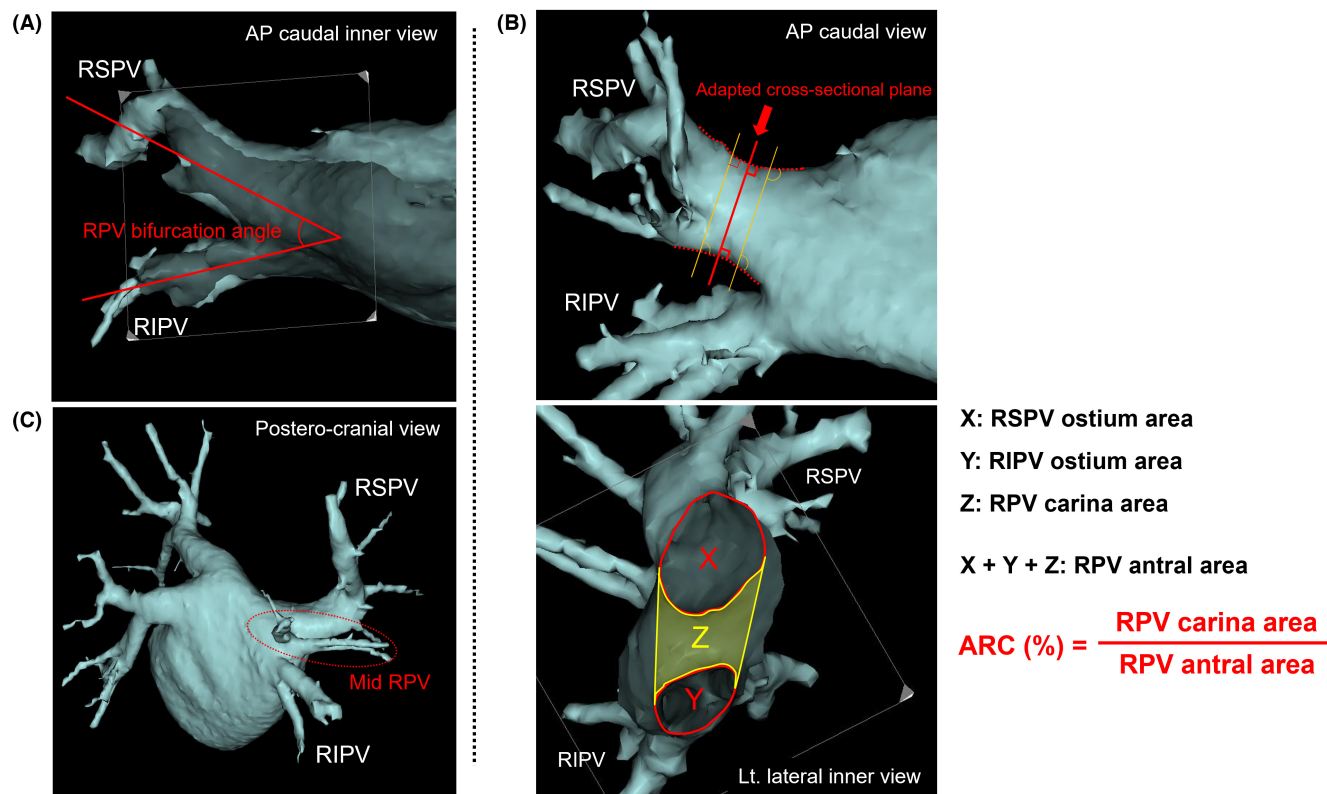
Analysis of anatomical characteristics of right pulmonary vein (RPV) based on computed tomography data. (Panel A) shows the RPV bifurcation angle, which was calculated as the angle between the lines which run longitudinally through the center of superior and inferior RPs in a cross-sectional plane. (Panel B) shows the area occupation ratio of the carina region to the RPV antrum (ARC), which was calculated as the area ratio of the carina to the RPV antrum. (Panel C) shows the presence of mid-RPV, which was defined as a pulmonary vein (PV) for which the ostium originates from the carina region, not from the trunk of each superior or inferior RPV.
